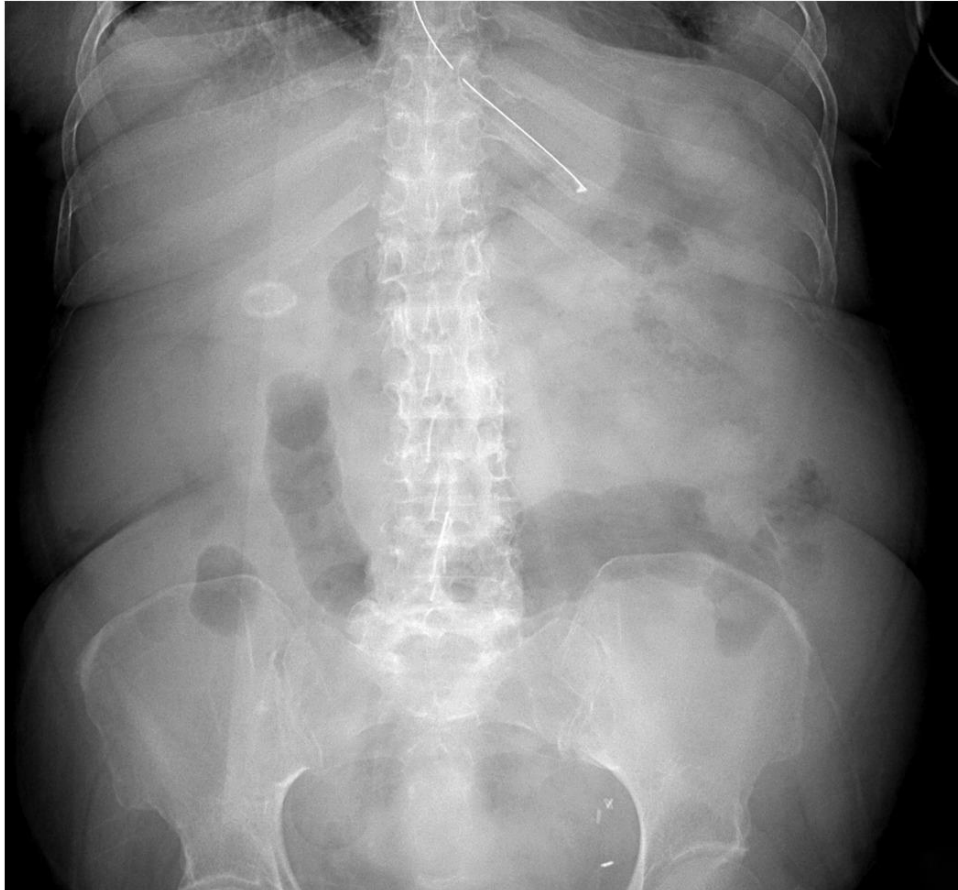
Frontal radiograph of the abdomen demonstrates a round, peripherally dense calcification in the right upper quadrant. An enteric tube is seen overlying the stomach.
